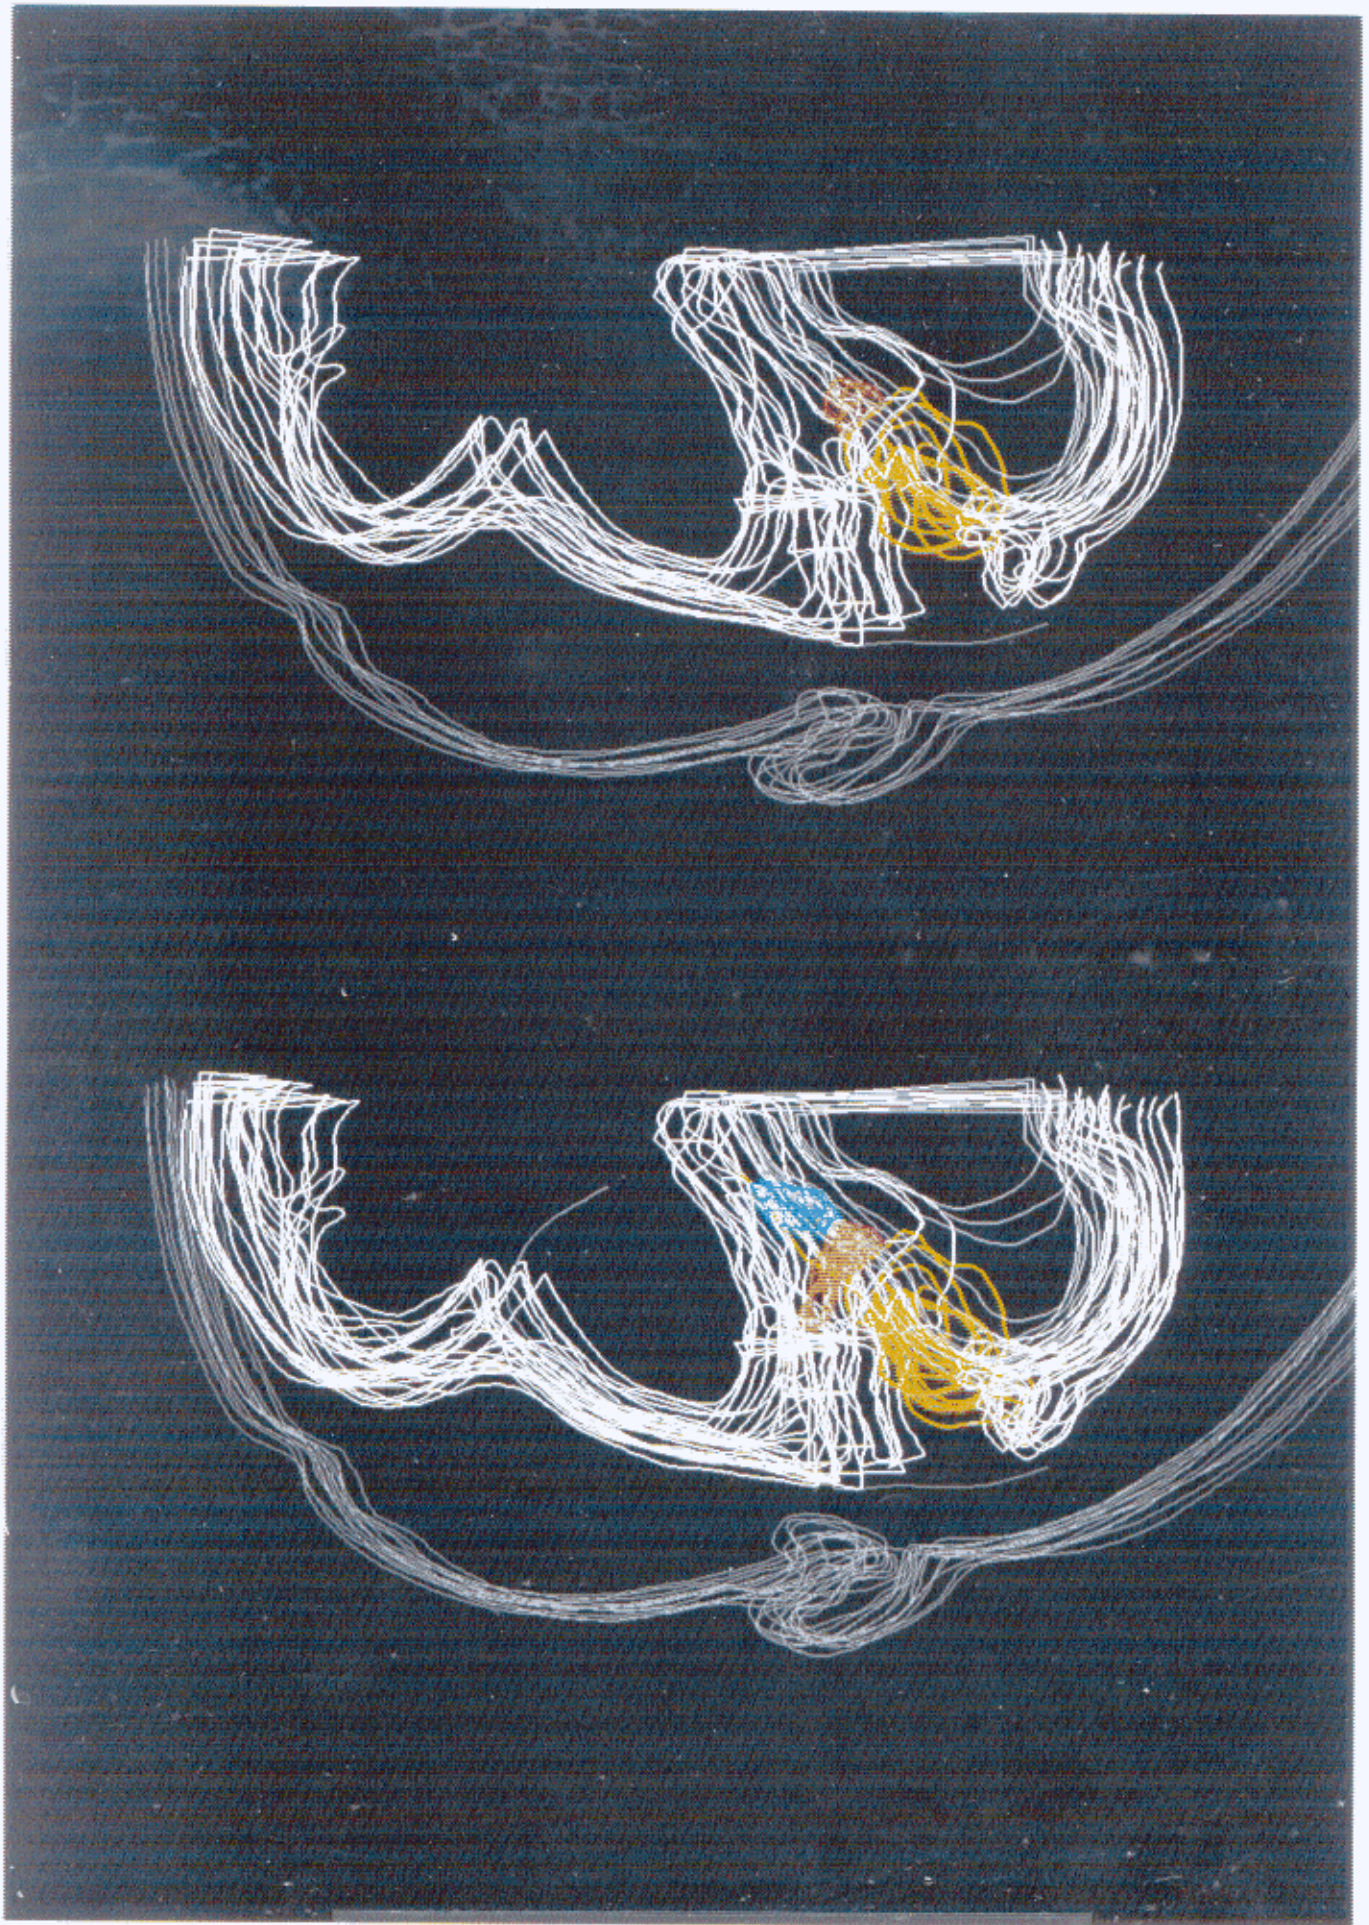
3D reconstruction of CT images
